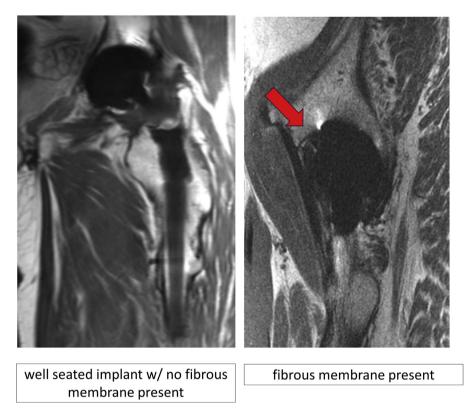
MAVRIC MRI demonstrating bony fixation (left) and fibrous membrane (right). Assessment of bony fixation and fibrous membrane % for 3D additively manufactured (Trident II) and 2D (Trident) cups.
